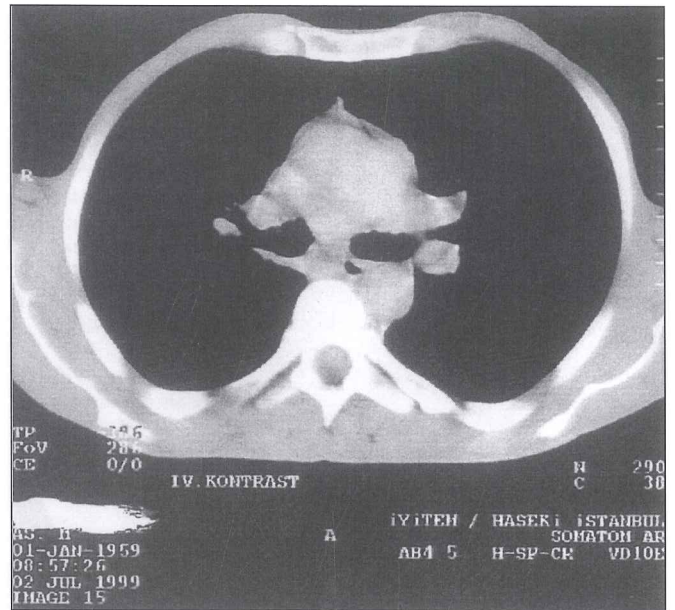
The chest CT scan showing distortion and nodular densities in the left and right main stem bronchi.
